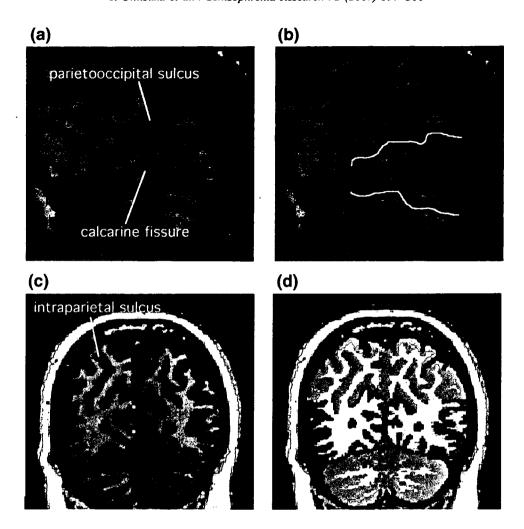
Sagittal and coronal MR images showing delineation of PVA and VAA. (a) The rater identifies the parietooccipital sulcus and the calcarine fissure on the midsagittal plane. (b) The yellow lines are the guidelines extending the sulcal courses used to delineate PVA and VAA. (c) On a coronal slice PVA and VAA are delineated by referring to the guidelines (yellow dots). In part B, here shown as yellow dots. On the lateral surface, the parietal lobe and occipital lobe are operationally separated by extending the guideline (the red dot) horizontally and medially across the tissue bridge of white matter horizontally and medially up to the intraparietal sulcus. (d) A coronal view of PVA and VAA delineation. White matter and gray matter were shown in light yellow and light blue respectively. The gray matter of PVA is shown in orange (subject left) and purple (subject right). The gray matter of VAA is shown in red (subject left) and blue (subject right).
